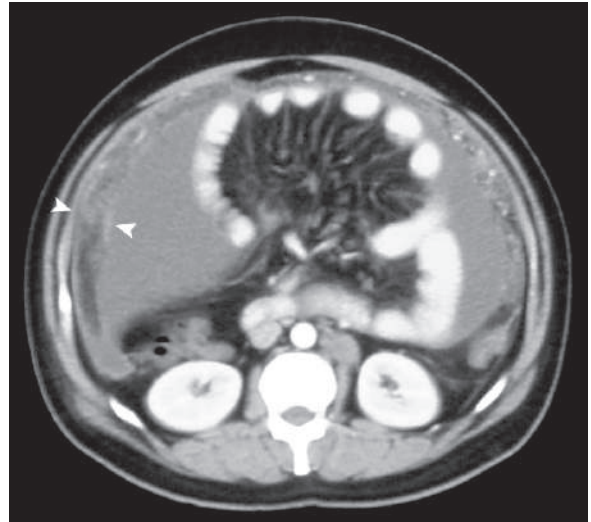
Axial postcontrast abdominal CT of a patient with TB peritonitis shows thickened peritoneum and enhanced omentum (*arrowheads*) representing the “omental cake sign,” with massive abdominal ascites. The same radiological picture can be caused by lymphoma
